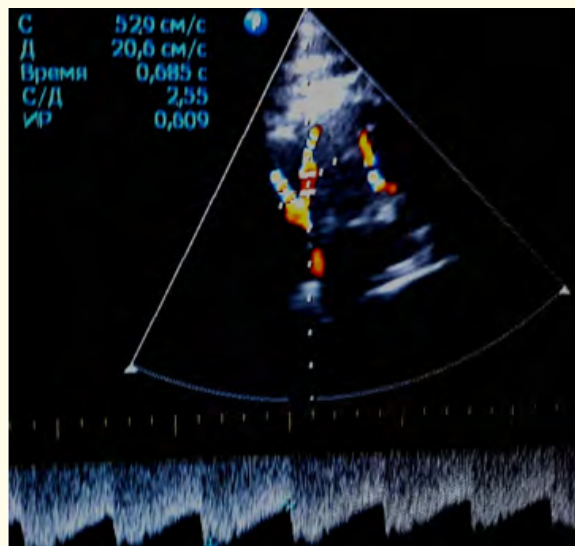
Doppler spectrum of the blood flow in fourth segment of the vertebral artery in neutral position of patient. Vs is 52,9 cm/c, RI - 0,61.
